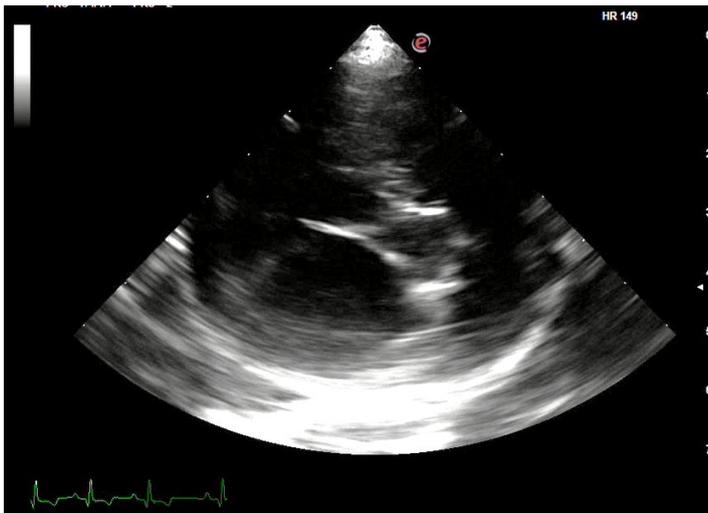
Right parasternal short axis view showing enlarged left atrium and pulmonary artery during end-diastole. LA, left atrium; AO, aorta; PA; pulmonary artery; RVOT: right ventricular outflow tract
